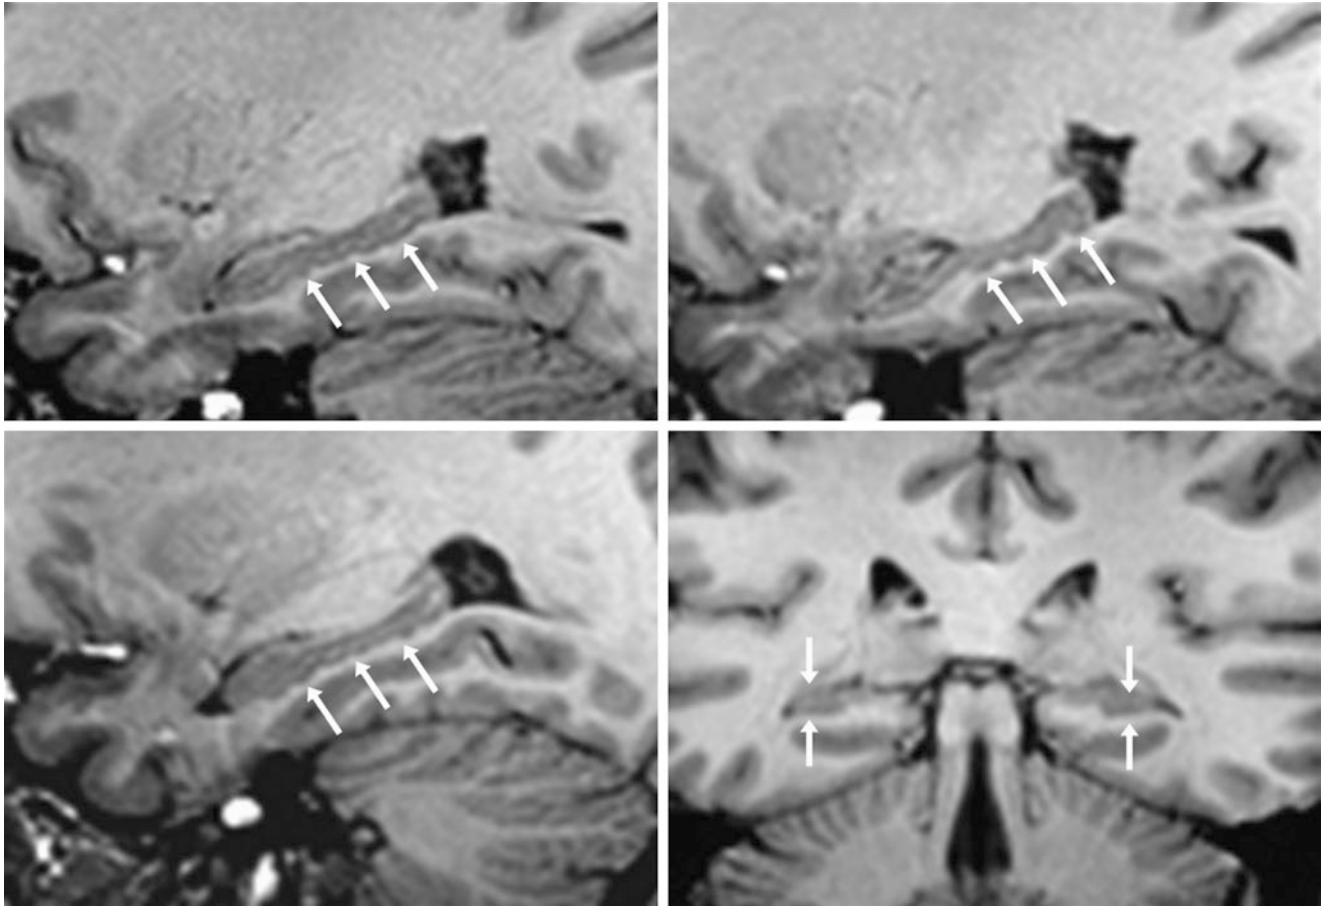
A 39 year old who had a corrugated or undulating configuration of the hippocampi bilaterally (*arrows*) on a 3 T MRI, with 1-mm-thick sagittal T1WIs of the left (*top row*) and right (*bottom left*) sides. A
